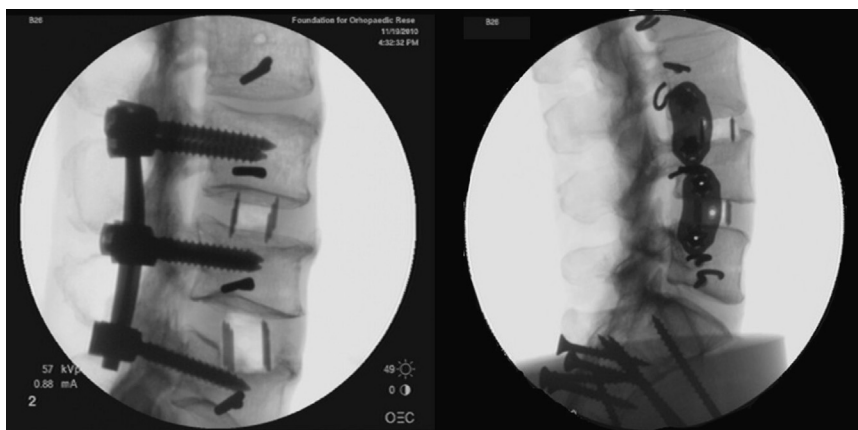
Radiographic representative images of 2 endplate fractures sustained during lateral interbody cage implantation.
